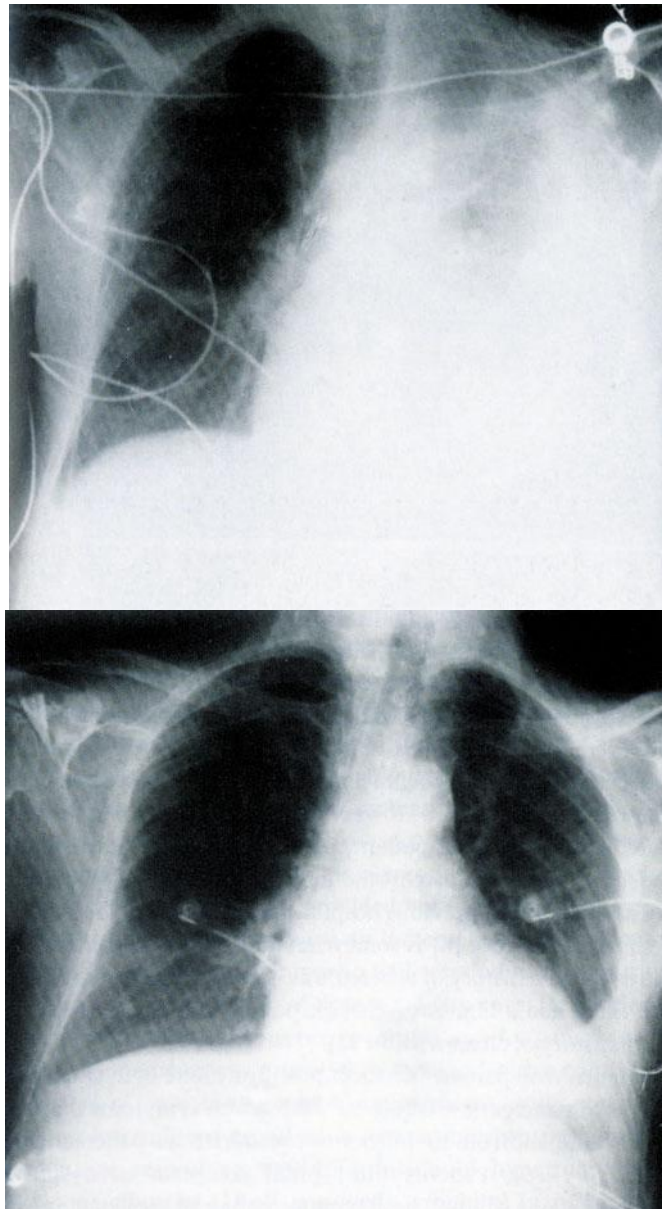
Radiographs of the chest of the patient cells with PH (according to P.A. Lipsett et al, 1998 [8]):
